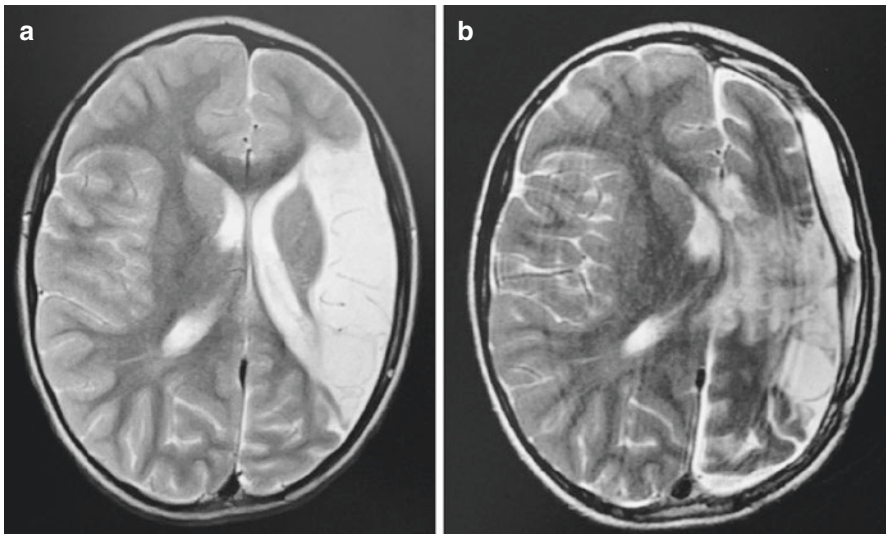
(a) Axial MRI of a patient with a left perinatal infarct; (b) Axial MRI of that same patient after undergoing functional hemispherectomy
